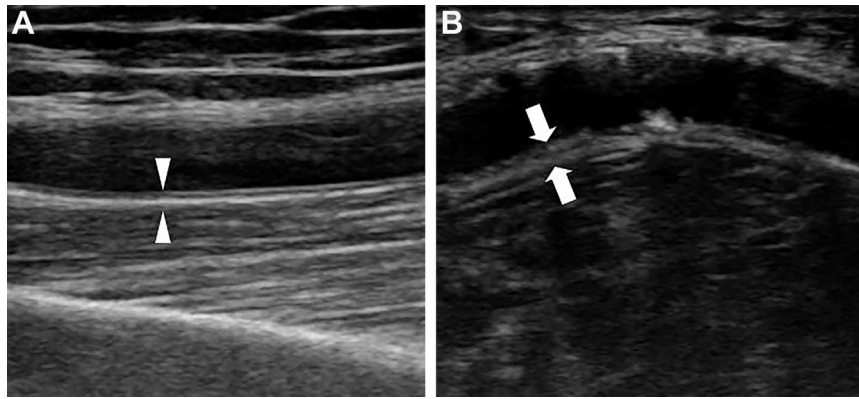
Representative ultrasound imaging. (A) A longitudinal image shows intima and medial layers of brachial artery without calcification (*arrowheads*). (B) A longitudinal image shows calcifications in the medial layers of brachial artery (*arrows*).
